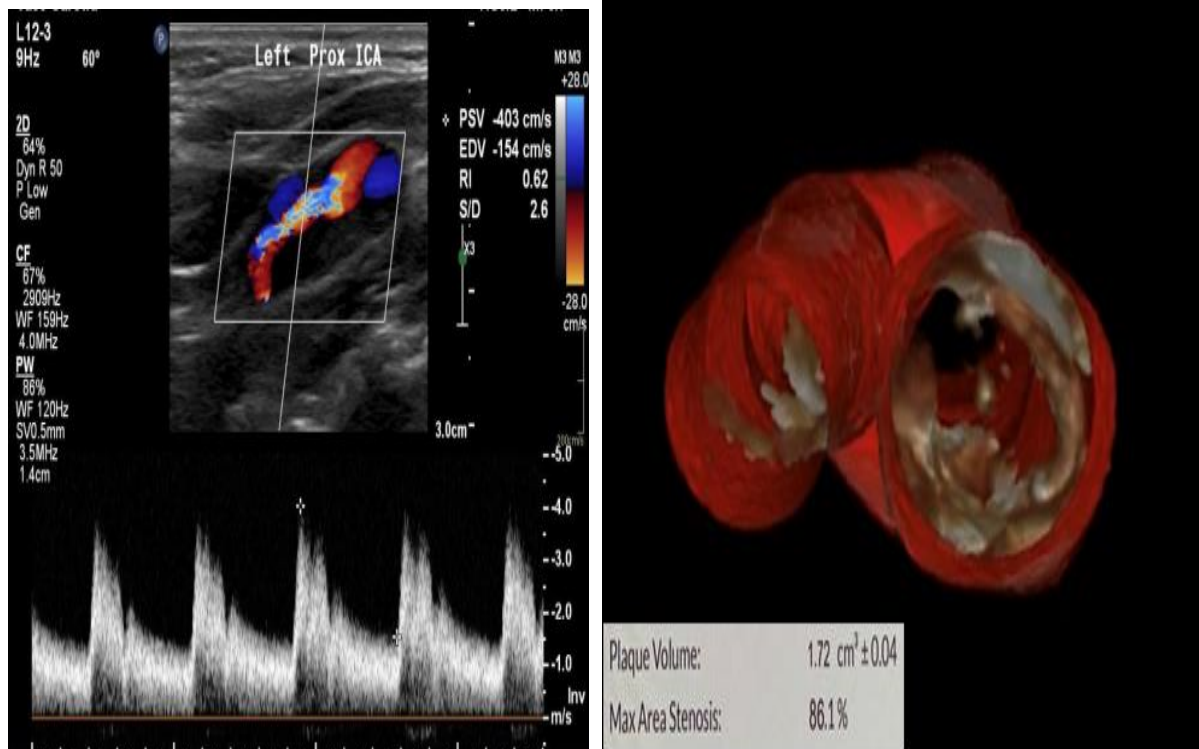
1 Measurements of peak systolic velocity in 2DUS (A), plaque volume and maximum percentage of stenosis in t3DUS (B) in the internal carotid artery. 2DUS: 2D ultrasound; t3DUS: tomography 3D ultrasound.
